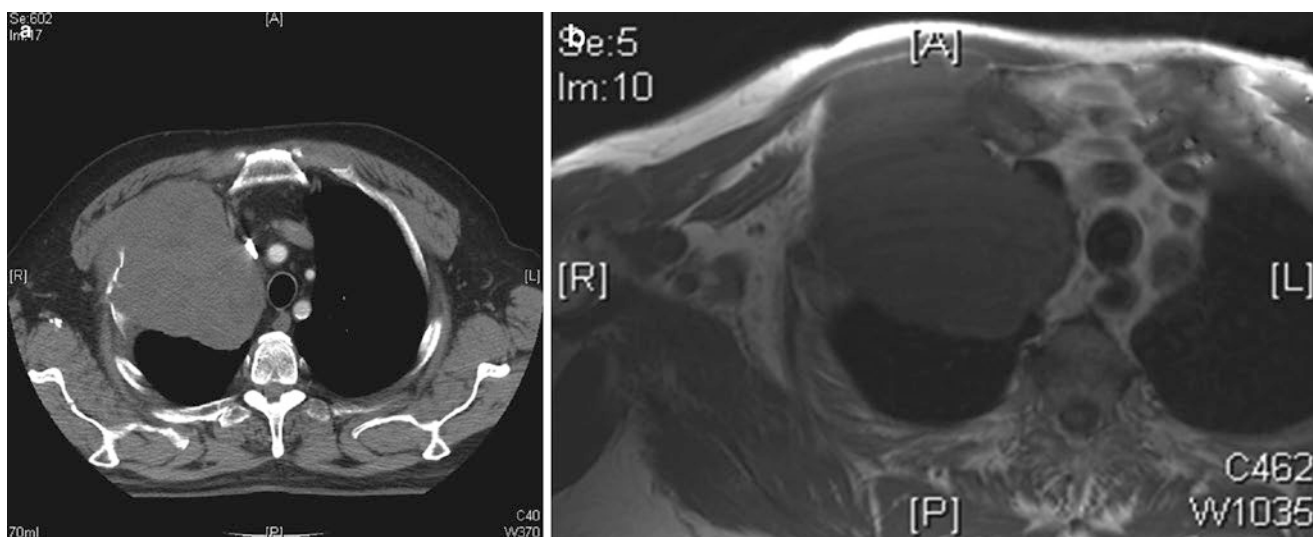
(a) Unusual solitary dominant mass. Note chest wall invasion through intercostal muscles. (b) MRI showing chest wall invasion
